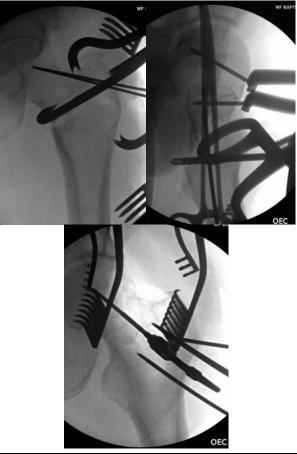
The open reduction technique guided by C-arm and provisional fixation with K-wires under x-ray guidance from the lateral incision
